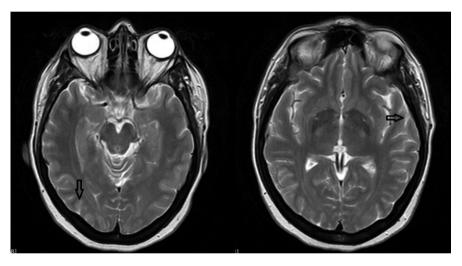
Axial view showing bilateral occipital, parietal and subcortical white matter T2/FLAIR hyperintensities.
